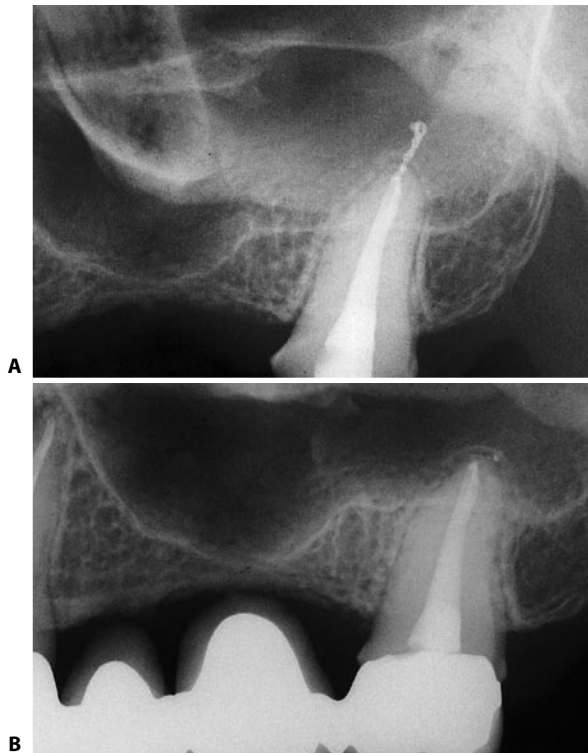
A. Postoperative radiograph of an upper left second molar. B. Eight months later: the excess material is no longer present.
